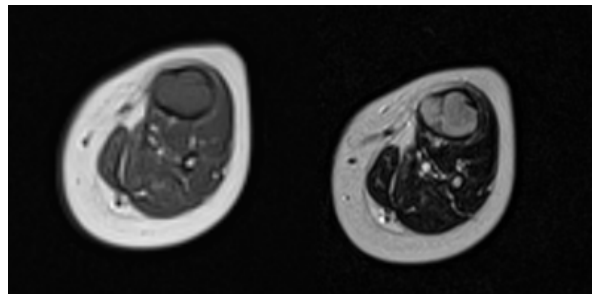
Axial T1- and T2-weighted images show diffuse heterogeneous intermediate signal mass (arrows) replacing entire medullary space
